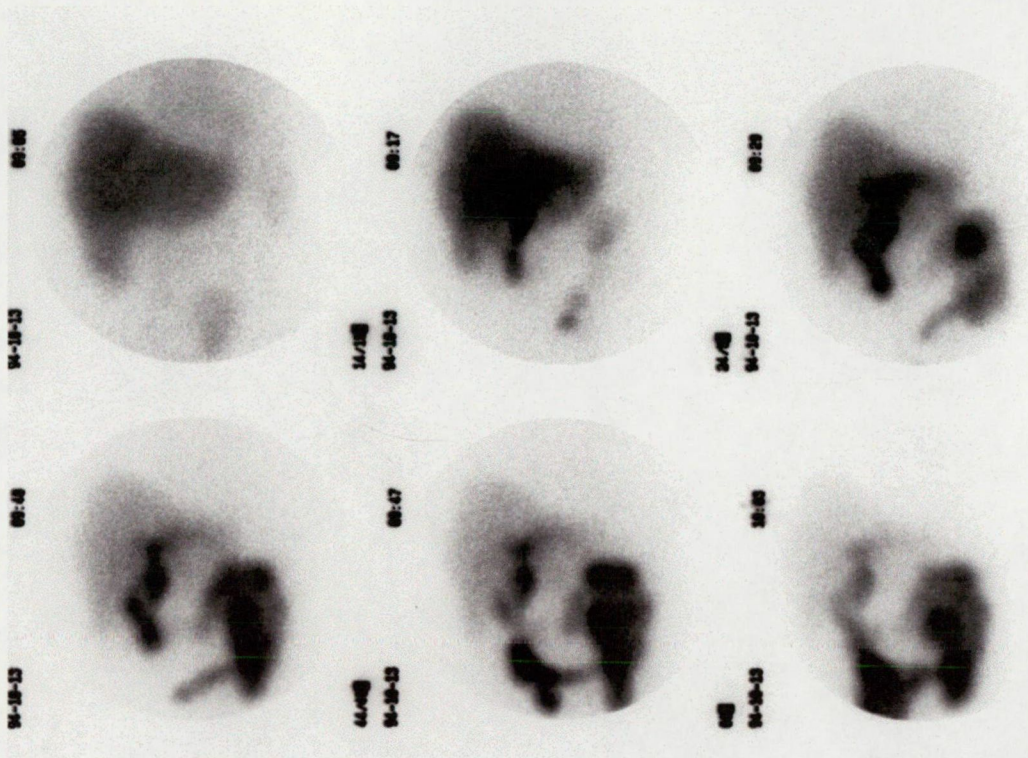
Representative hepatobiliary scintigraphy recording in a cholecystectomized patient with a normal liver size, a normal hepatic uptake of the radioactivity, with rapid excretion into the bile ducts, and obviously free transpapillary bile flow, without signs of extrahepatic biliary obstruction.
